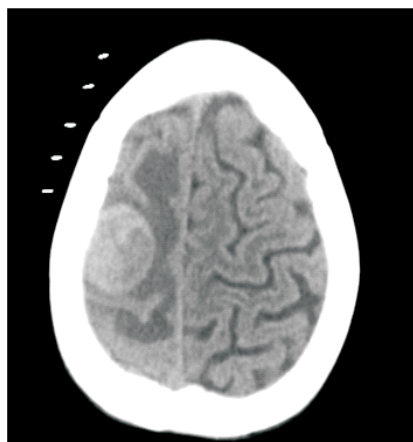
Preoperative CT head showing right motor strip lesion
